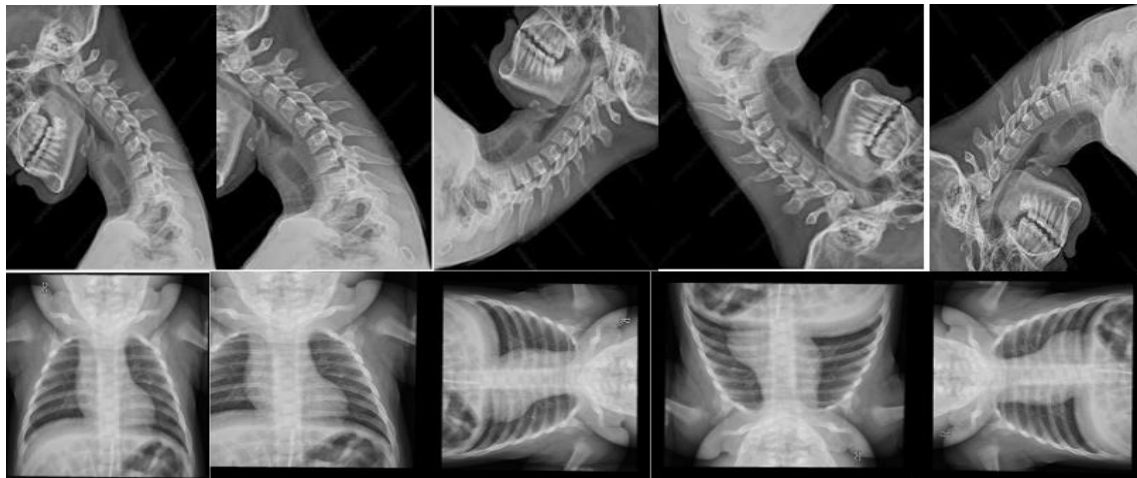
neck and chest radiographic basic resize and transformation; from left, original image, resized image to 100 x 20, 900 rotated image, 1800 rotated image and 2700 rotated image.
